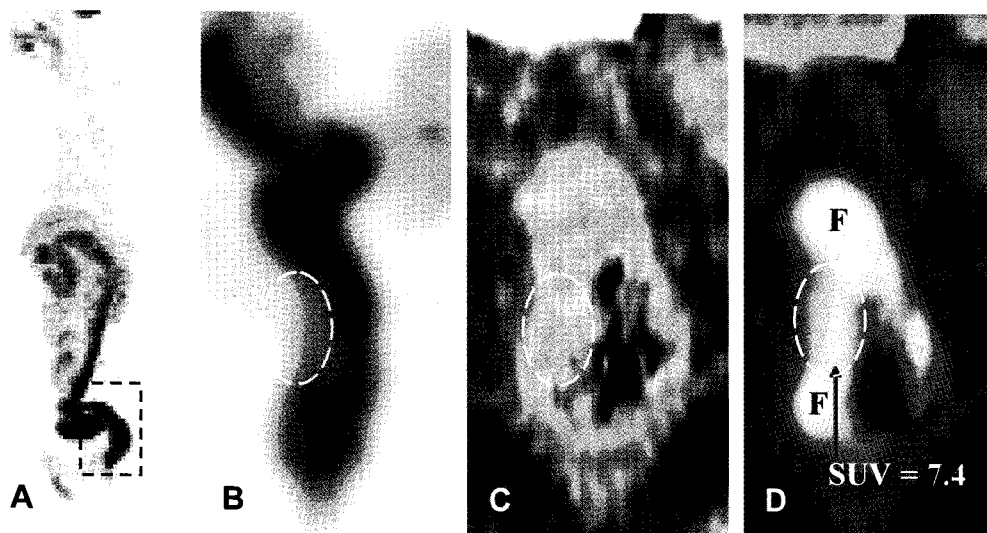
A. Lateral maximum intensity projection image of torso shows no filling defect in the mid-rectum that is diffusely filled with feces and mucus (frame). B. Near-lateral magnified view shows shallow filling defect (circle) in the right posterolateral aspect. C. Magnified CT scan shows segmental thickening of the rectal wall (circle). D. PET scan shows moderately increased ¹⁸F-FDG uptake (SUV = 7.4 max) (circle). F denotes feces.
